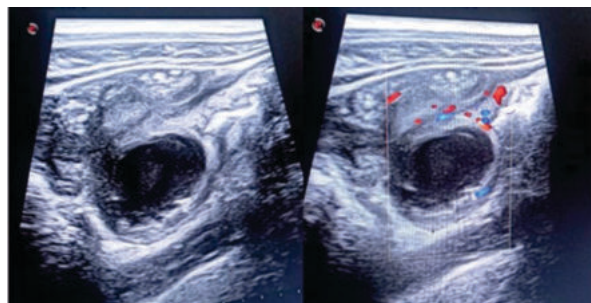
Ultrasound Images Showing Thick Walled, Hypoechoic Lesion In Close Proximity To Cecum With Increased Mesenteric Vascularity On Color Doppler.
